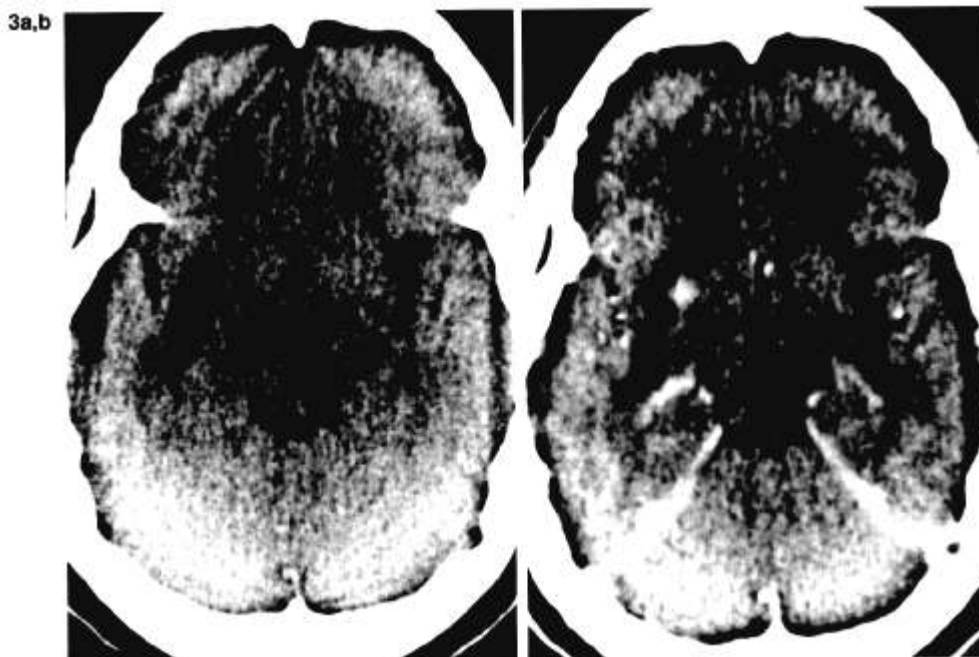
a: Plain CT is normal. b: Postcontrast CT shows focal enhancement in the right basal ganglionic area (arrows). Midbrain and thalami are normal.
